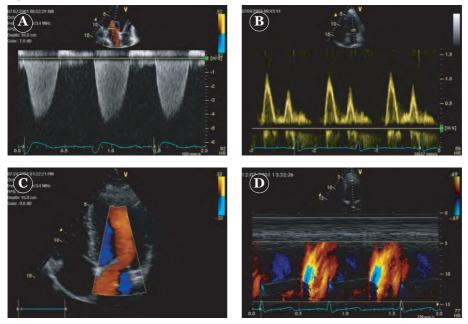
Various Doppler imaging modalities: Continuous wave (A), pulsed wave (B), colour flow mapping (C) and colour M-mode imaging (D).
